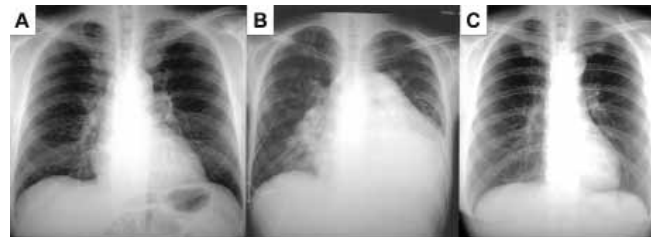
Preoperative chest x-ray films of the recipient and the two donors showed similarity in size. A, Right lower lobe donor; 51-year-old father. B, Recipient; 19-year-old daughter. C, Left lower lobe donor; 50-year-old mother.
